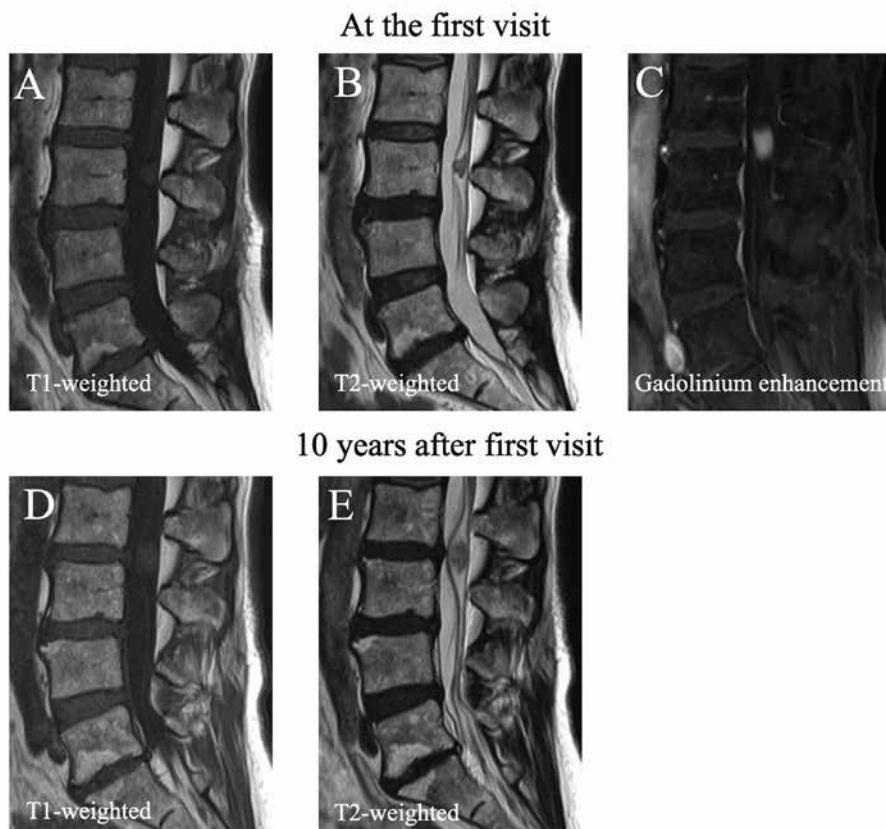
Magnetic resonance images obtained at the first visit (A, B) and immediately before surgery (10 years after first visit, C–E). (C) The tumor shows diffuse gadolinium enhancement. (A, B, D, E) show tumor growth and extension from the L3 to L2/3 level.
